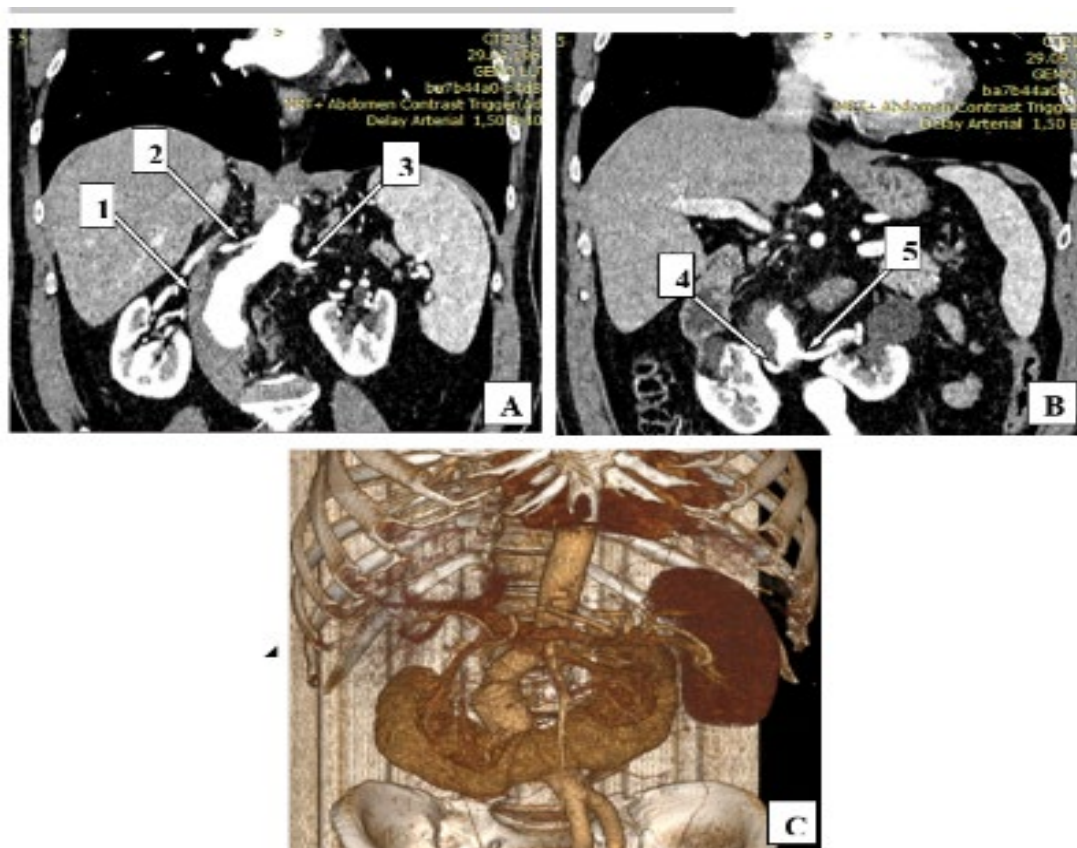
Abdominal CTA: A – AAA (1), main renal arteries (2,3); B – additional renal arteries (4,5); C – 3d-reconstruction of AAA and HSK
